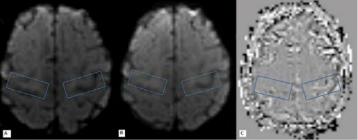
An Example of One study Subject (A): DWI Sequence Pre-stimulation; (B): DWI Sequence Post-Stimulation; (C): ADC Subtraction Map (Pre and Post) of same slice.
